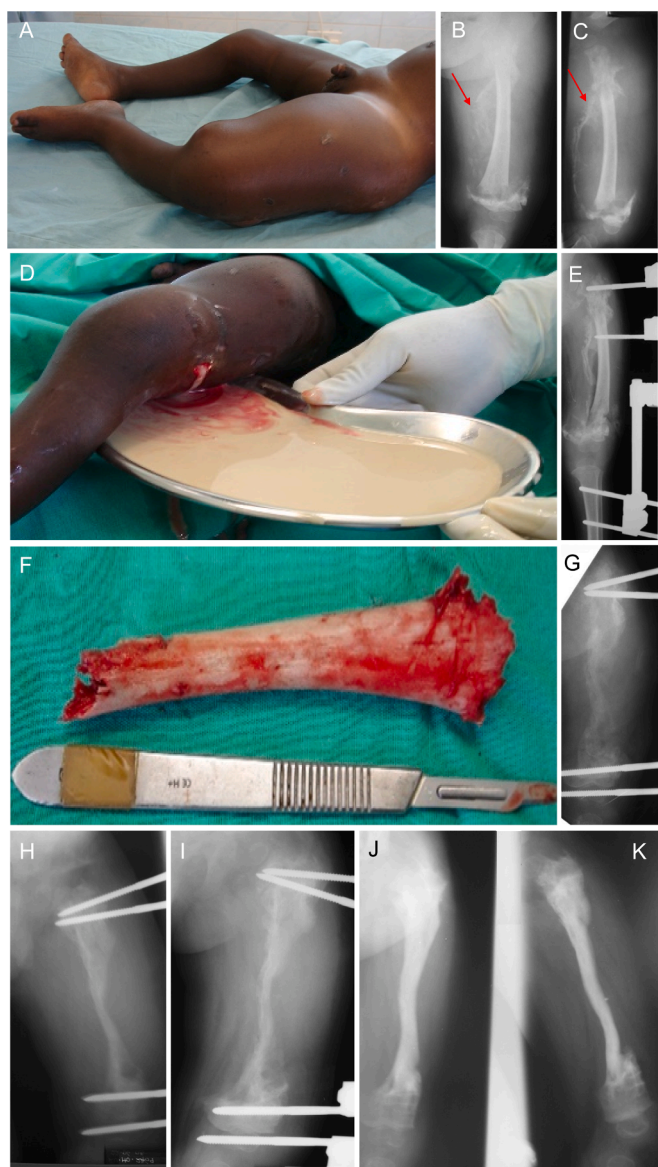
Clinical presentation of a 2 years old boy with sepsis from an underlying osteomyelitis at the left femur. He presented with a severe soft tissue swelling with pseudoparalysis of the left lower extremity associated with high fever and shivering as symptoms of sepsis (A). X-rays showed sequestration of the entire femoral diaphysis with pathological fractures at both ends (B and C). Starting new bone formation at the medio-dorsal aspect of the femur is already visible on ap (B) and lateral (C) radiographs (red arrows). Incision and drainage of the abscess formation were carried out in emergency and a lot of pus was drained (D). The sequestrum was initially left in situ, acting as an anchor point for the proximal pins. Two pins were also inserted in the tibia so as to extend the knee joint. Four weeks later, the new bone formation had progressed significantly in the meantime (E). A sequestrectomy of the femoral diaphysis was performed (F) and a new femoral fixator was applied (G). Follow-up X-rays at 3 (H), 8 (I) and 13 (J and K) weeks showed progressive bone formation with remodeling of the of the entire femoral diaphysis and preservation of the femoral length.
